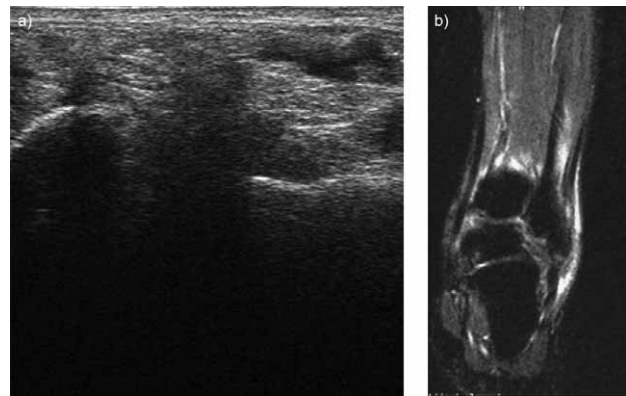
a) (Ultrasound). Stretching (Lesion G1) of the left Long peroneal muscle tendon; 5.b) (Magnetic resonance). Stretching (Lesion G1) of the left Long peroneal muscle tendon.
